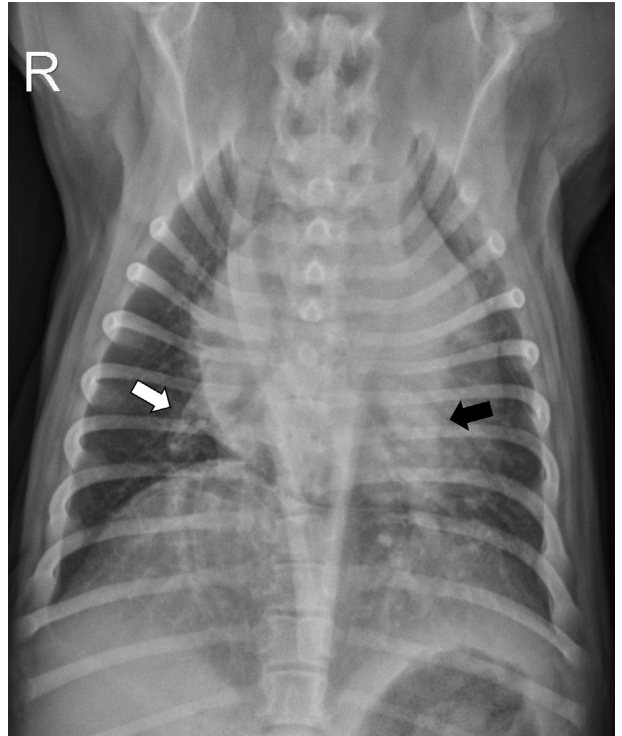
Thoracic radiograph, dorsoventral projection. The right caudal lobar pulmonary artery (*white arrow*) and the left caudal lobar pulmonary artery (*black arrow*) are highlighted, demonstrating notable enlargement of the latter.
